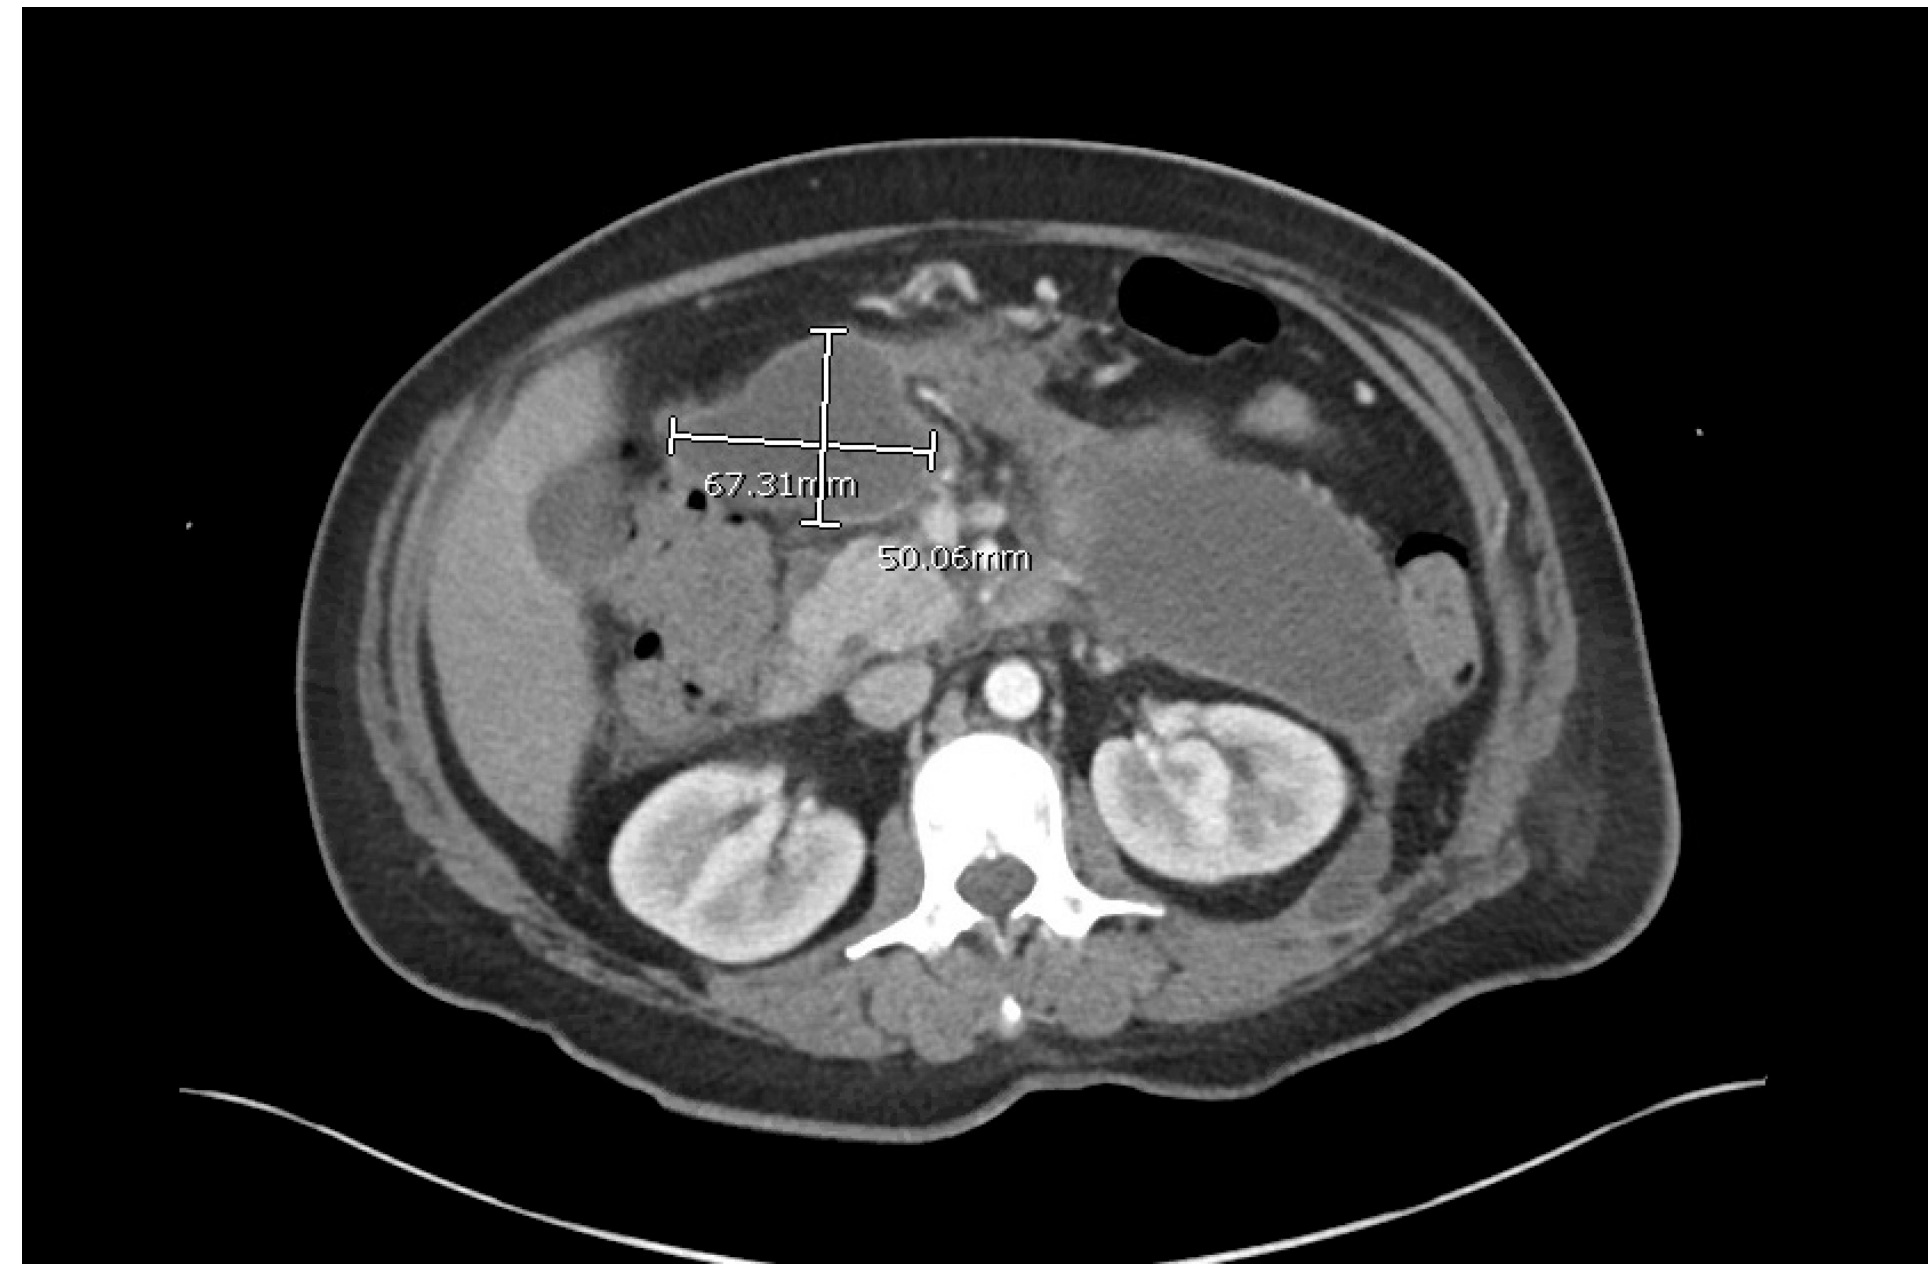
CT Abdomen and Pelvis w/ Contrast showing an intraperitoneal collection anterior to the pancreatic head
